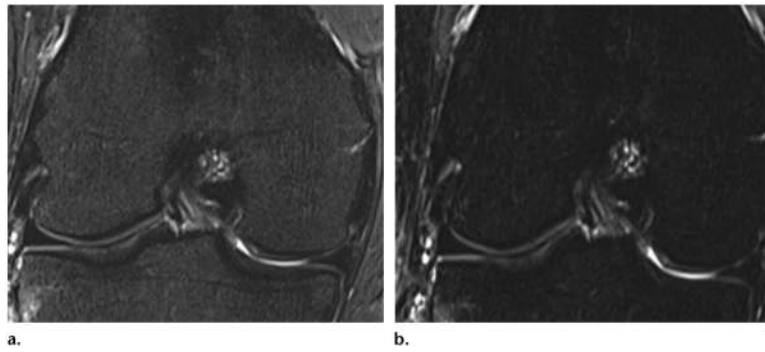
Effects of STIR imaging in the knee. (a) STIR MR image (TR, 4500 msec; TE, 27 msec; TI, 205 msec) shows weak fat suppression of bone marrow. (b) STIR MR image (TR, 4500 msec; TE, 27 msec; TI, 220 msec) shows stronger fat suppression. (Images courtesy of Rory Johnson, RT, Siemens Medical Solutions, and Peter Cazares, Senior MR Education Specialist, Siemens Medical Solutions.)
